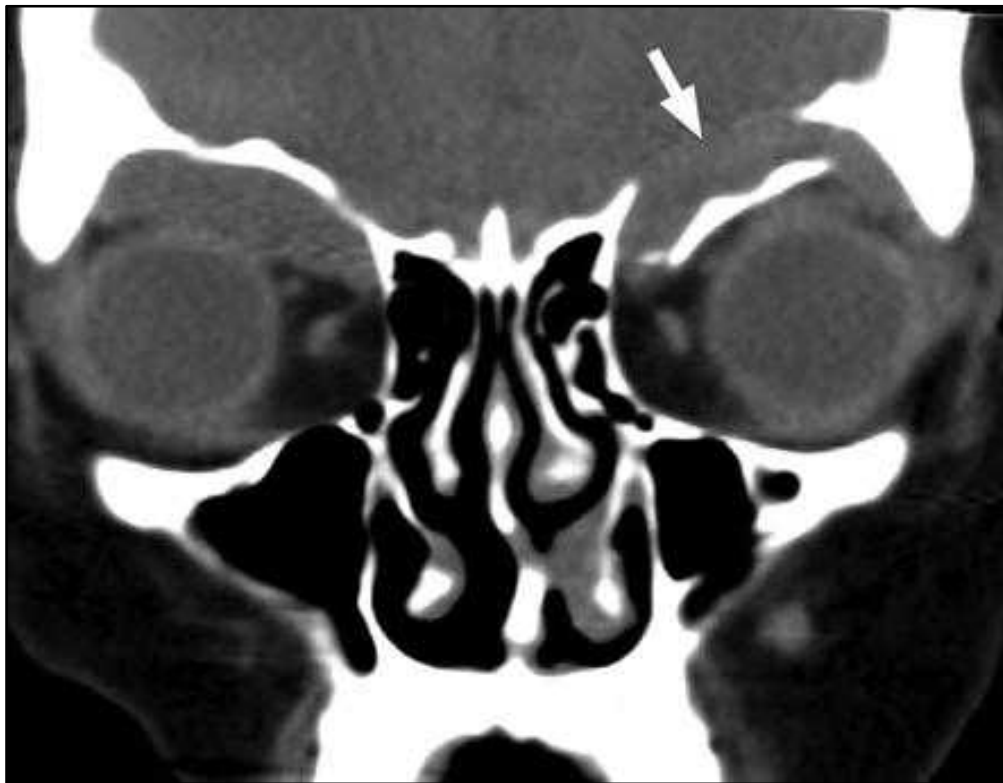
Orbital roof fracture in an adult. Coronal non enhanced CT image shows an isolated blow-in fracture of the left orbital roof (arrow).
